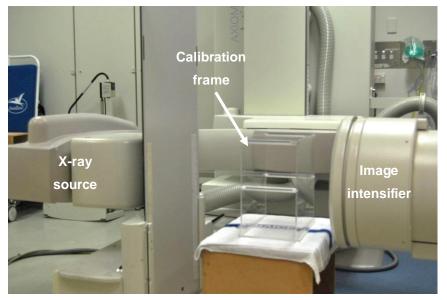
The AXIOM-Artis MP with the calibration frame. X-ray source: X-ray generator, powering the X-ray tube, which contains a filament that once heated, produces electrons that are accelerated towards a tungsten component which releases X-rays, the Collimator determines the size of the X-ray beam. Image intensifier: transforms X-rays into light, which is recorded by a camera, where the light is transformed into an electric signal sent to a monitor (not shown in the picture).
